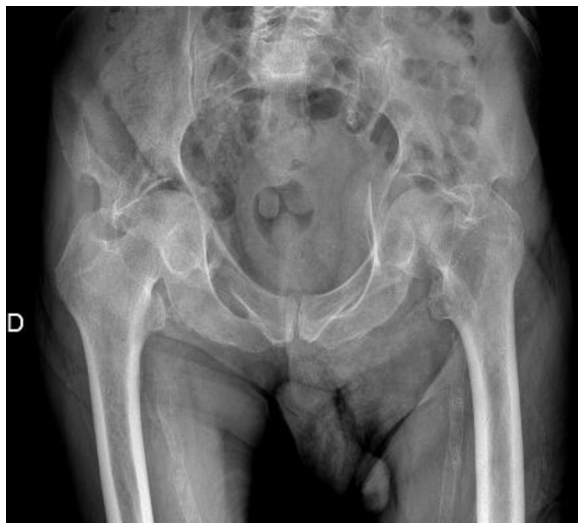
Anteroposterior pelvis radiograph showing bilateral acetabular fractures with subluxations of the femoral heads.
